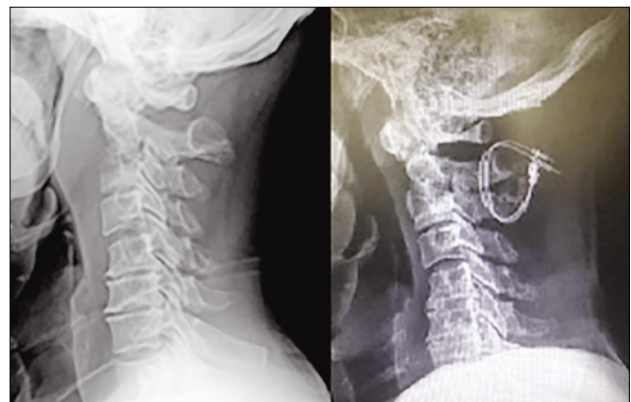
Profile image of the pre and postoperative radiography.
